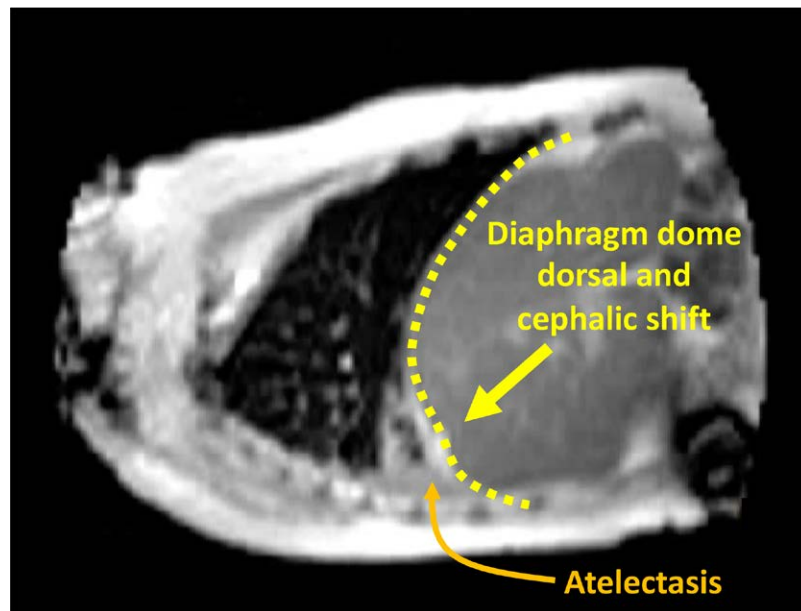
Sagittal cross-section magnetic resonance images showing the effect of general anesthesia and paralysis in the supine position: dorsal cephalad shift of the diaphragm dome and atelectasis of the dorso-caudal lung.
